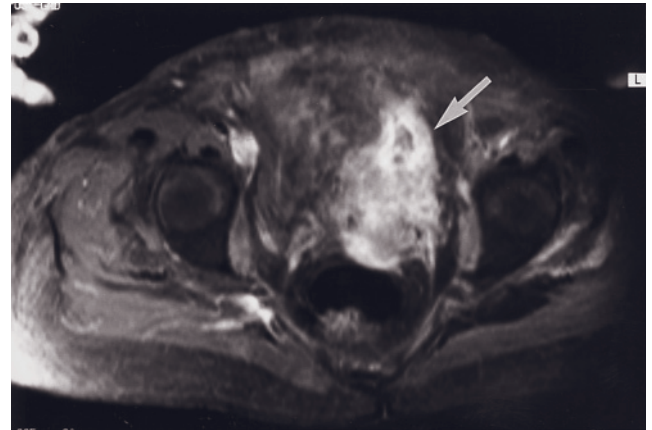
Vaginal carcinoma at 1.5 and 3 T. Sagittal (a) and transverse (b) T2-weighted ETSE and sagittal (c) and transverse (d) interstitial-phase gadolinium-enhanced fat-suppressed SGE images at 1.5 T. There is a large, irregular soft tissue mass arising from the vagina and involving the urethra (arrows, a–d). The uterus is small and low signal secondary to prior radiation therapy. In a second patient, transverse T2-SE (e) and interstitial-phase gadolinium-enhanced fat-suppressed 3D gradient echo (f) images at 3 T show an irregular, enhancing, partially necrotic vaginal mass (arrow e, f).
